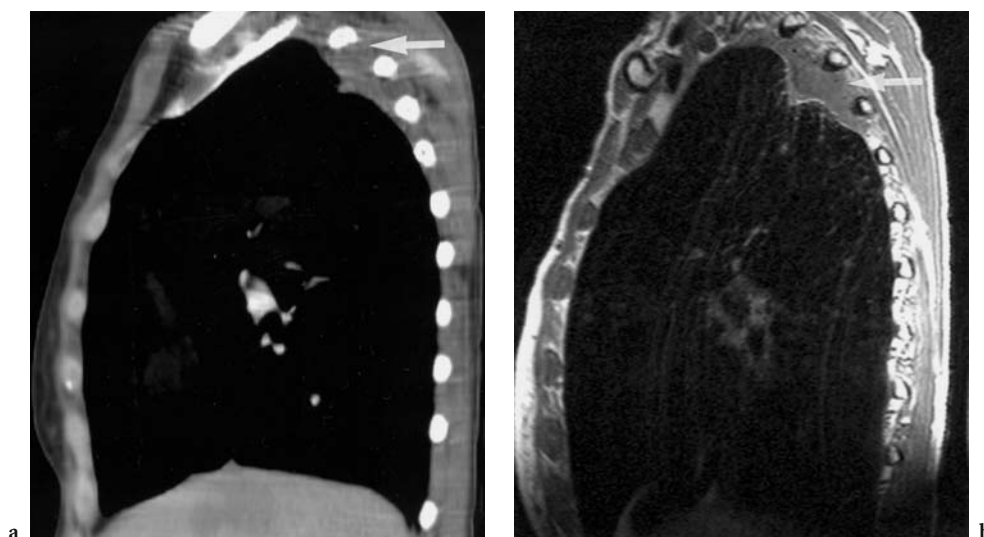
Chest wall invasion from peripheral lung cancer on CT and MR imaging. a. Sagittal multiplanar reformation CT image demonstrates peripheral mass in right upper lobe, with extension into chest wall (arrow) between upper posterior ribs. Chest wall invasion was not well demonstrated on the original axial images. b. Sagittal T-1 weighted MR image of same patient. The higher contrast resolution of MR results in slightly better demonstration of the tumor infiltrating the fat between the posterior ribs (arrow)
